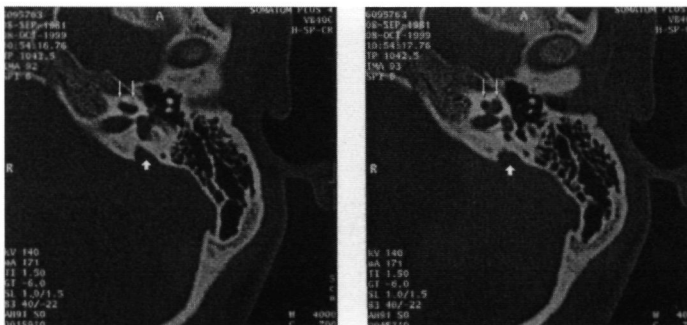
CT scans of the inner ear in the Pendred syndrome. The widened vestibular aqueduct is shown by a broad white arrow. The hypoplasia of the cochlea is shown by two small white arrows.
